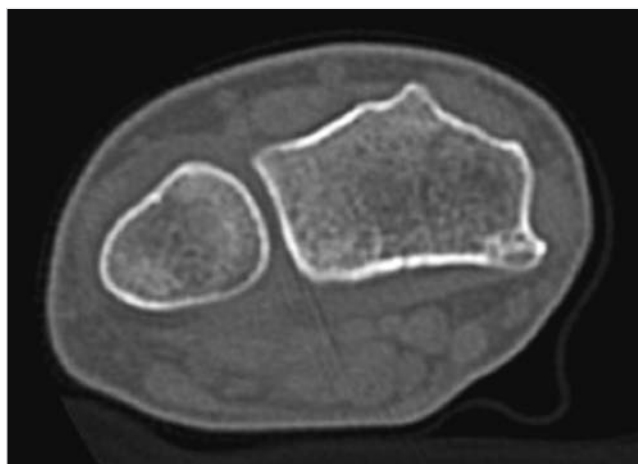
CT scan shows a flattened sigmoid notch, with substantial deficiency of its volar rim.
